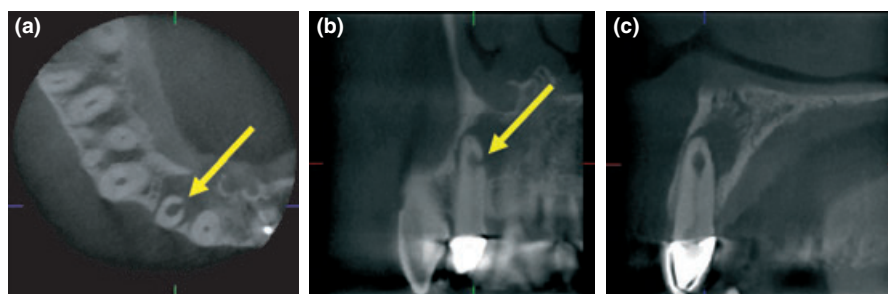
Selected cone beam computed tomography images of tooth 12; (a) axial slice demonstrating palatal perforation (yellow arrow), (b) coronal slice shows location and size of perforating resorptive defect (yellow arrow) as well as the extent of the periradicular lesion, (c) further slice does not disclose perforation but clearly demonstrates 'classical' appearance of internal root resorption.
